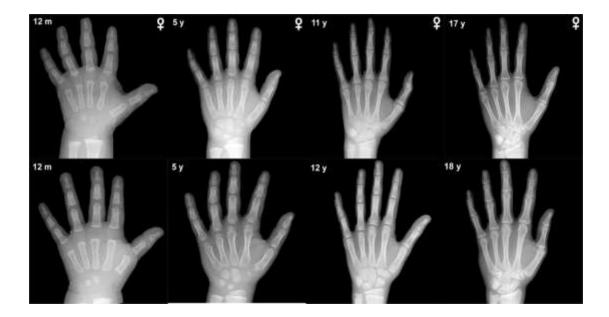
Excerpt from GP chart showing left wrist x-ray at various stages of development.
